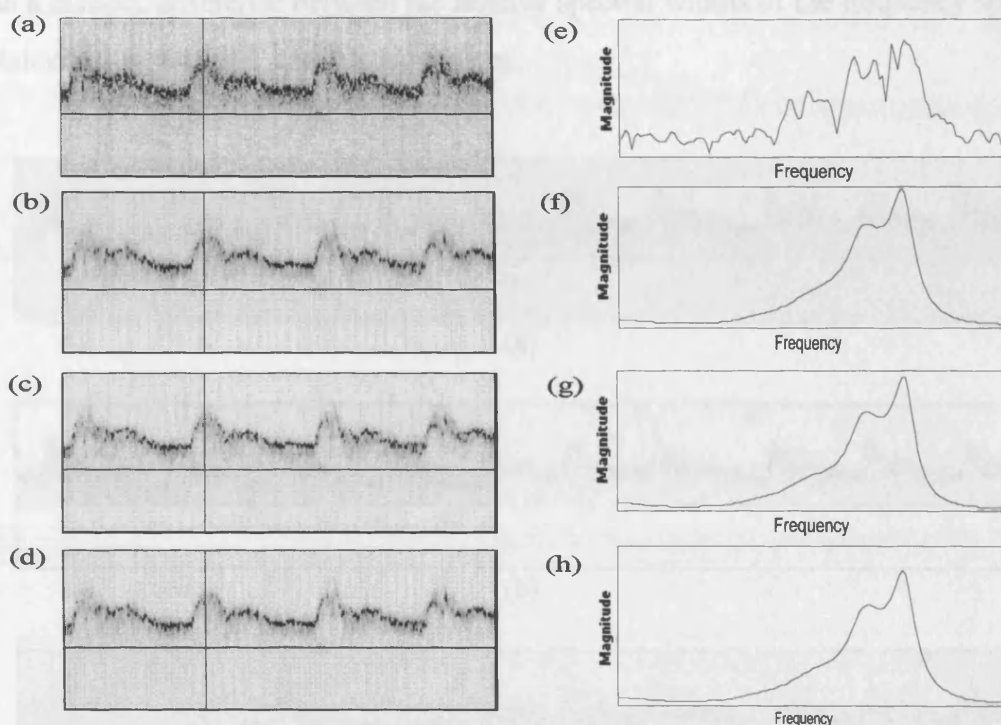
Sonograms of internal carotid arteries (ICA) using (a) FFT, (b) AR with Yule-Walker approach and eqn [7.1] for PSD, (c) AR with Yule-Walker approach and eqn [7.2] for PSD, (d) Burg and eqn [7.1] for PSD, (e)-(h) Frequency spectra taken from respective sonograms around the peak systole of the cardiac cycle (as marked with the vertical line on (a)-(d)).
